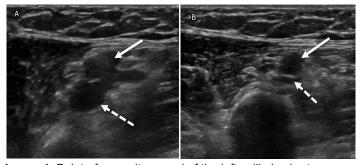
Point-of-care ultrasound of the left axilla in short axis using a 15-6 MHz linear probe: A) without compression; and B) with compression. The axillary vein (solid white arrow) demonstrates non-compressible venous structures with near-complete collapse of the concomitant artery (dotted white arrow).
